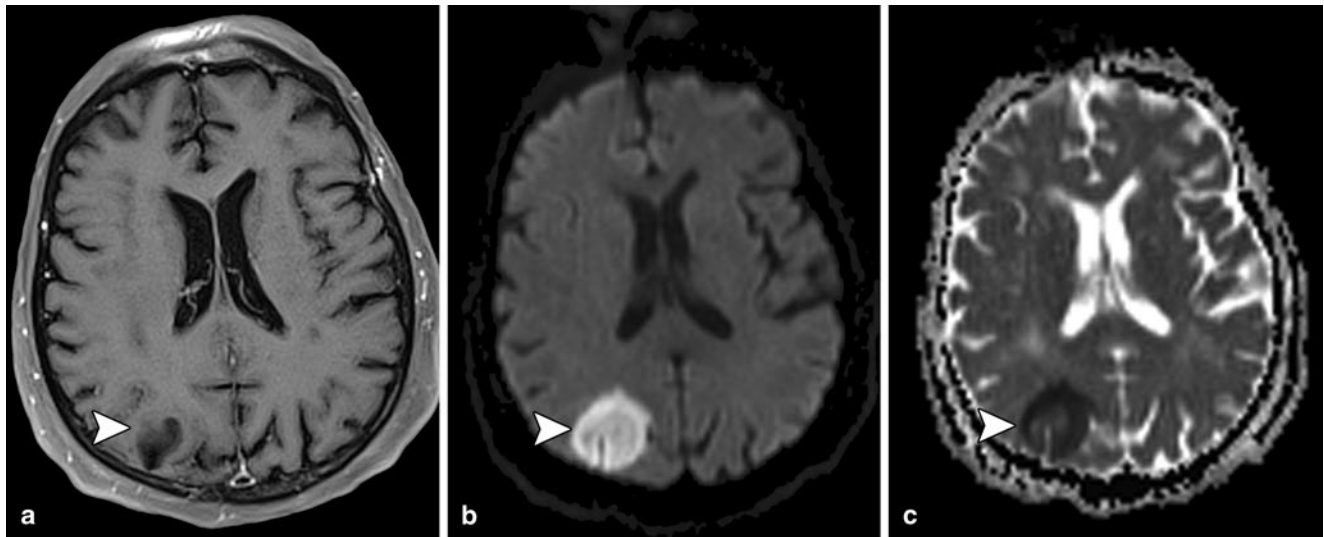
Reduced diffusion is often the first imaging finding in fungal infection, even preceding enhancement. a Axial T1 post-gadolinium, b DWI ($b = 1000 \text{ s/mm}^2$), and c apparent diffusion coefficient (ADC)-map (calculated from b values of 0 and 1000 s/mm^2) demonstrate minimal enhancement but obvious reduced diffusion (arrowhead).
